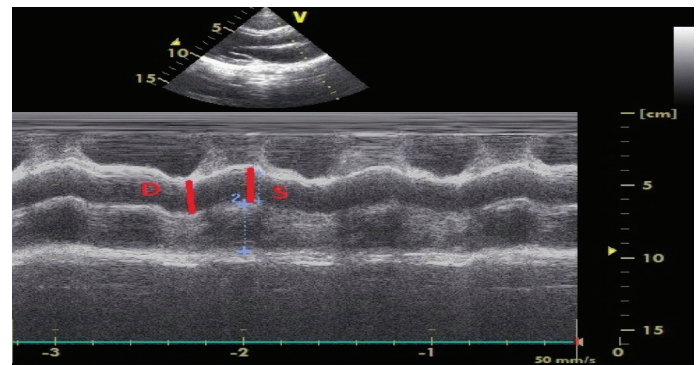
M mode transthoracic echocardiography view of systolic-diastolic diameters of the ascending aorta.
